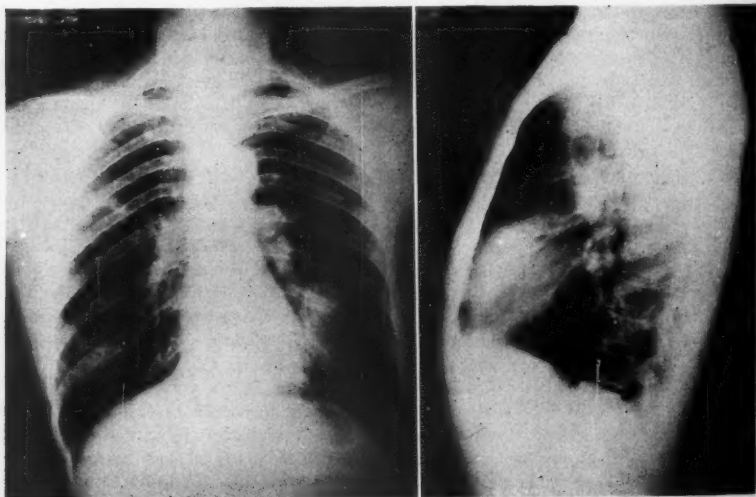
Case 3. Roentgenograms which reveal an area of density in the region of the lingula segment of the left upper lobe.
